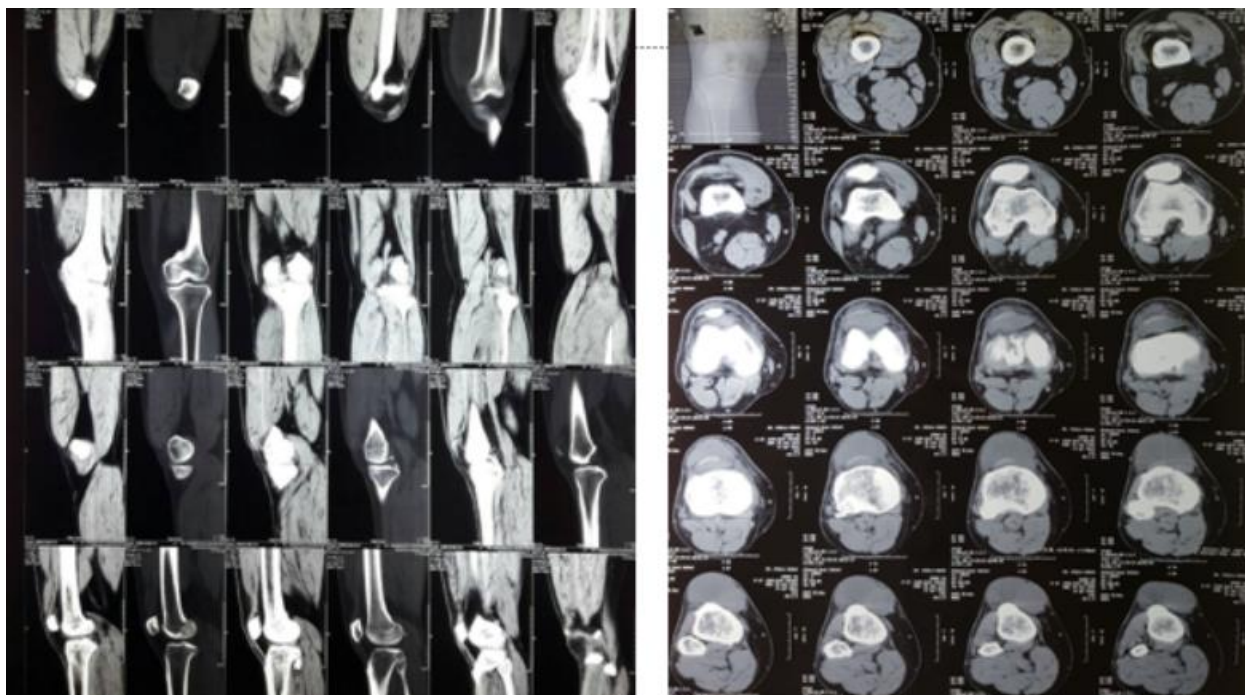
CT scan of right knee joint
